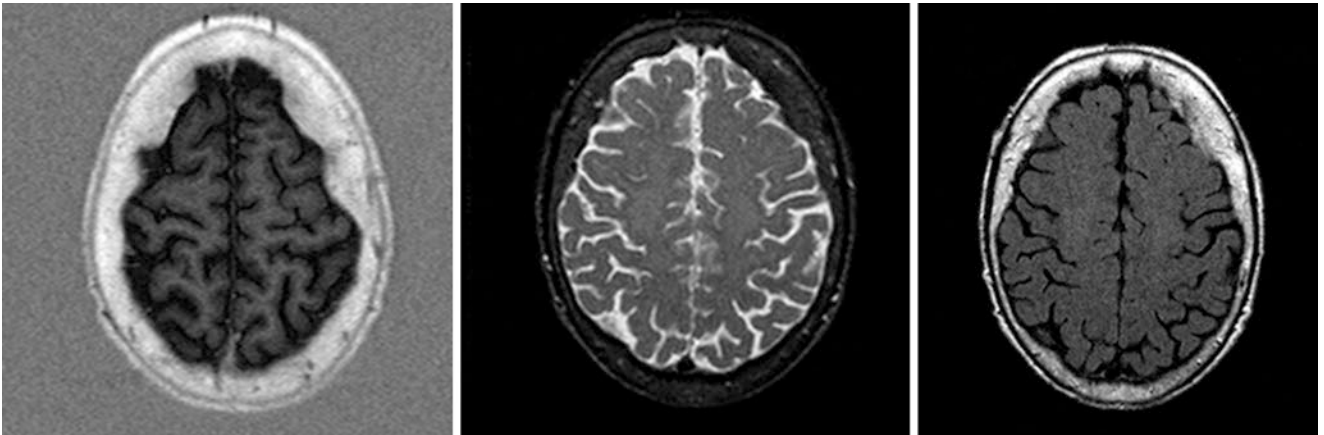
A 79-year-old female with HFI on T1- (*left*) and T2-inversion recovery (*middle*) and non-FS FLAIR (*right*) MRI
